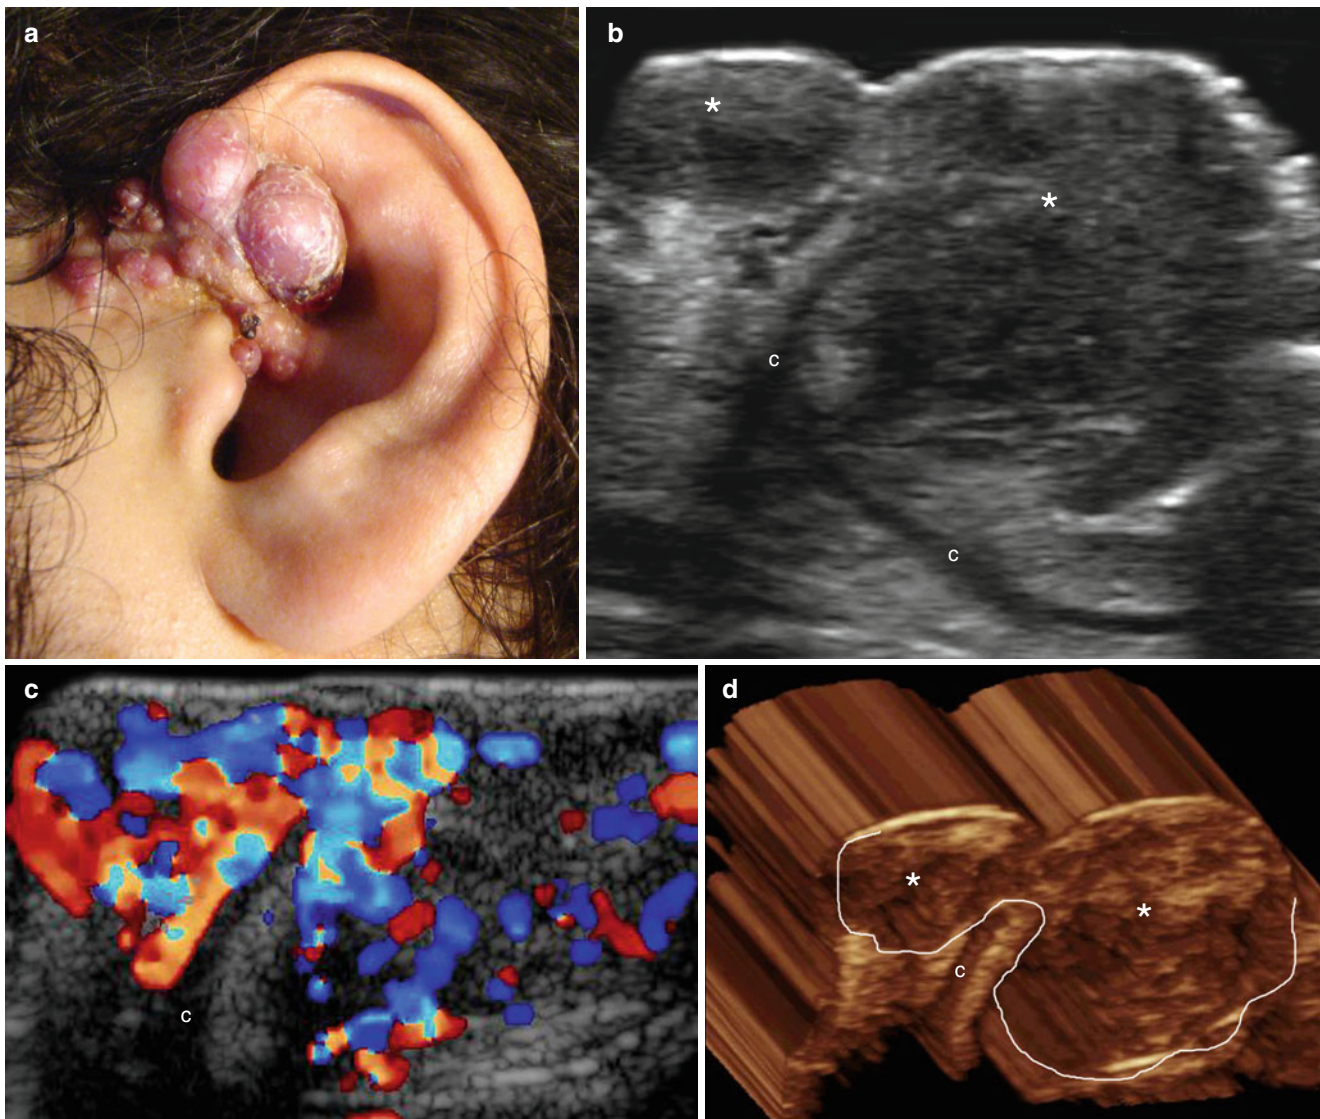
(a–d) Epithelioid hemangioma (angiolympheoid hyperplasia with eosinophilia). (a) Clinical lesion shows multiple erythematous bumps that affect the left ear pinna and pre-auricular region. (b) Grey scale ultrasound (transverse view) demonstrates hypoechoic and confluent nodules and pseudonodules (*) that involve the cutaneous
